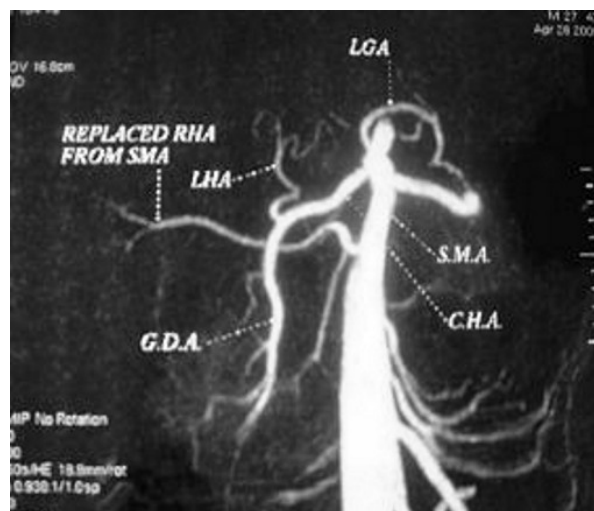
CT angiogram showing a replaced right hepatic artery arising from the superior mesenteric artery. CHA: common hepatic artery; GDA: gastroduodenal artery; LGA: left gastric artery; LHA: left hepatic artery; RHA: right hepatic artery; SMA: superior mesenteric artery
